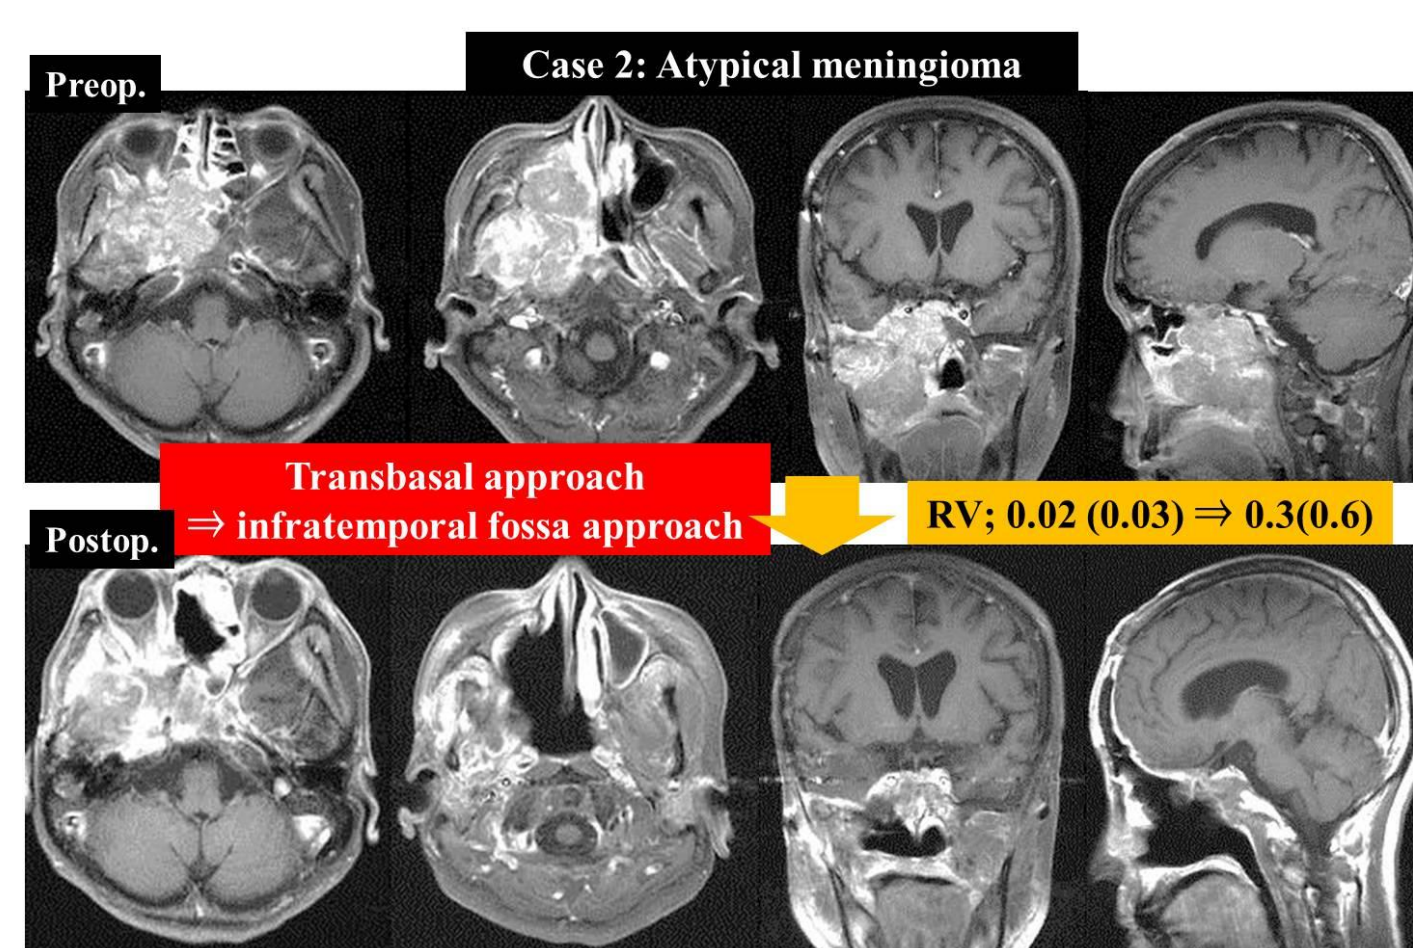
Pre- and postoperative MRI on Case 2
